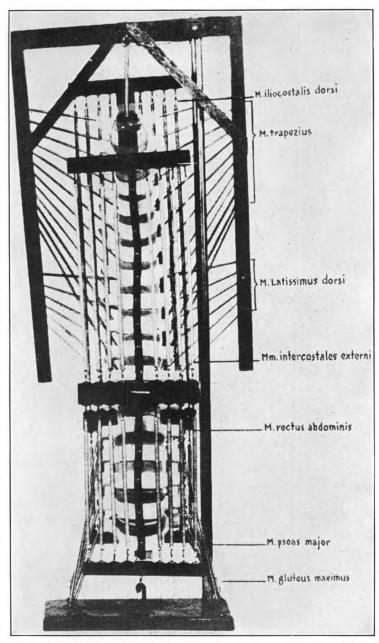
VENTRAL ASPECT OF THE DYNAMIC MUSCLE-BONE BALANCE MODEL OF THE HUMAN SPINE.
